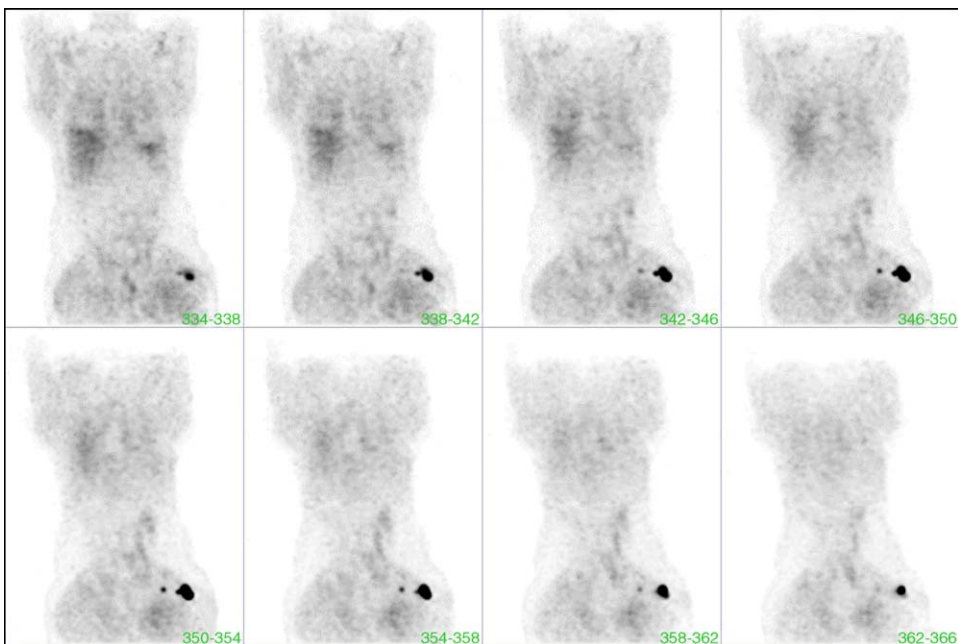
Coronal views of FDG-PET study show two focal areas of intense FDG uptake in the right iliac bone suggestive of bone metastases.
